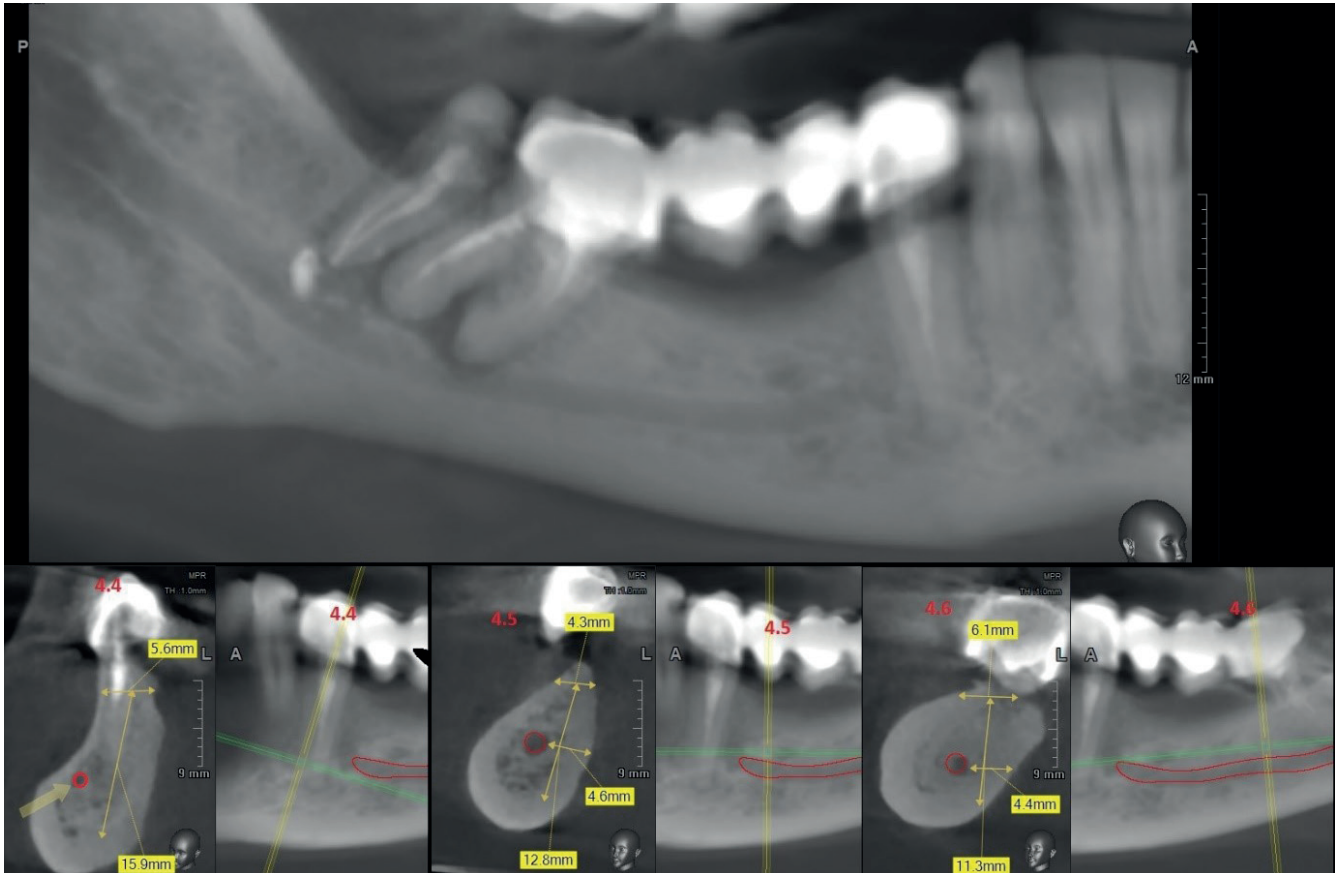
Reformatted CBCT scan, panoramic view. Patient S., born in 1972, before implantation. Chronical periodontitis of teeth 44, 47, 48. Graphic visualization of the mandibular canal with measurements of the height of the mandible and the distance from the mandibular canal to the lingual cortical plate.
